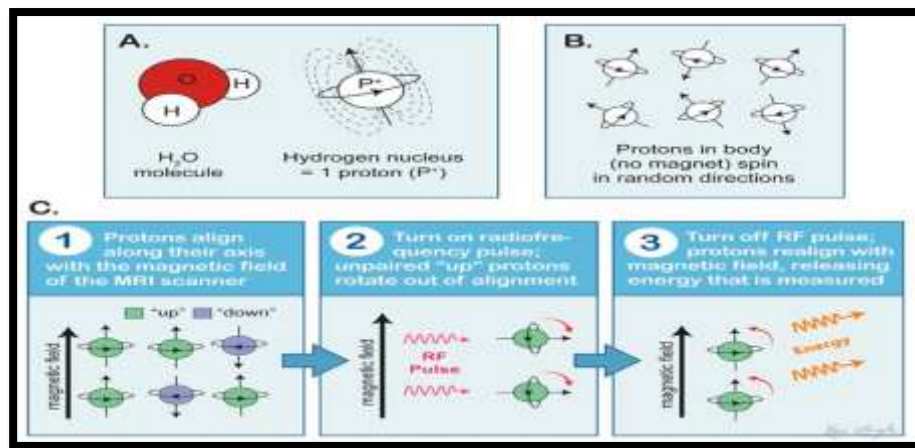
Representation of MRI working principle.
